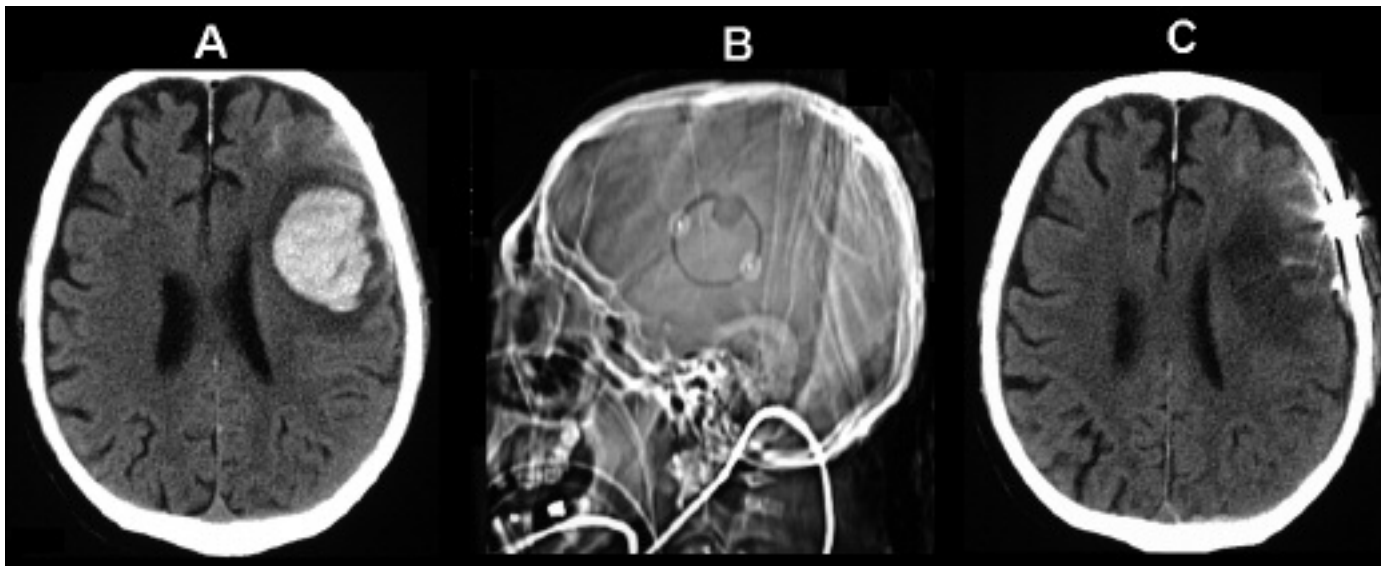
Early sSICH evacuation and hemostasis. A left frontal, warfarin related sSICH (A) resulted in hemiparesis, aphasia and generalized seizures. Emergent hematoma evacuation was completed within 4 hours of stroke onset, through an ultrasound guided craniotomy and mini-corticectomy (B). Intra- and post-operative hemostasis was readily achieved with administration of vitamin K, FFP and rFVIIa (C).
